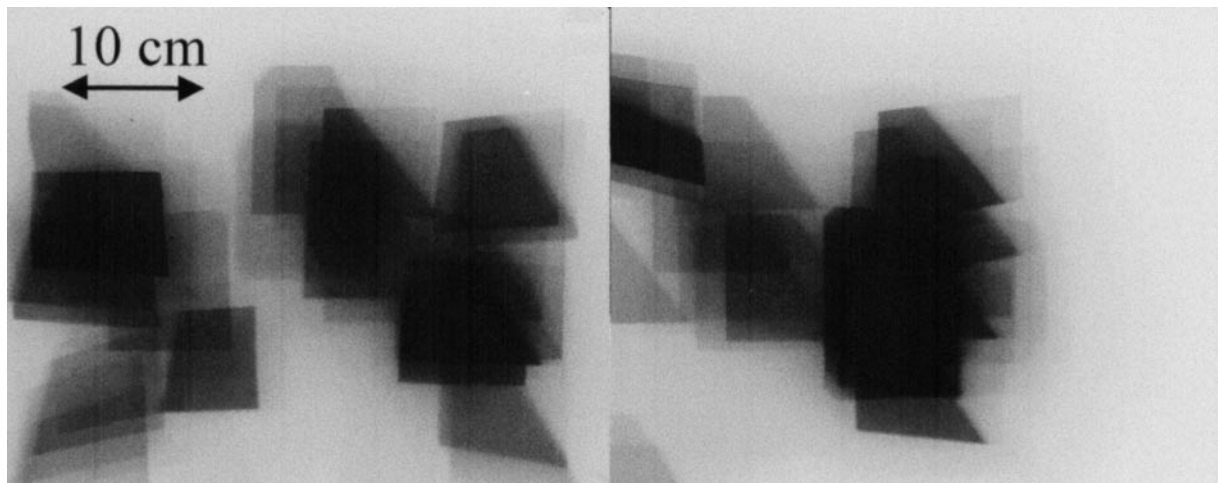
X-ray field images from coronary angiography procedures performed in facility HC-O. Procedure No. 27 (right) yielded a dose-area product (DAP) of 40.3 Gy cm² and a maximum skin dose (MSD) of 296 mGy, with a mean field size of 71 cm² and a total irradiated area of 836 cm². Data from procedure No. 57 (left) were 44.1 Gy cm² DAP and 161 mGy MSD with a mean field size 90 cm² and a total irradiated area of 900 cm². Note that DAP and mean field size were higher in No. 57 for a similar irradiated area, but that MSD was higher in No. 27 owing to higher field concentration. Accordingly, the concentration factor is 6.2 for No. 27 and only 3.3 for No. 57.
